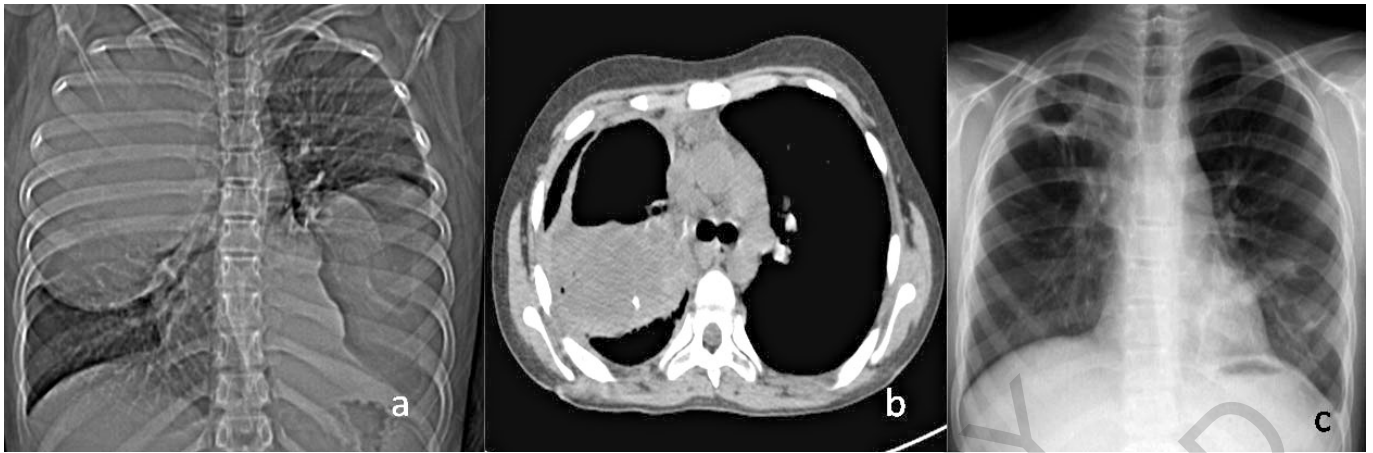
A) Preoperative view of the cyst; B) Bronchopleural fistula; C) Chest x-ray after right upper lobectomy.
